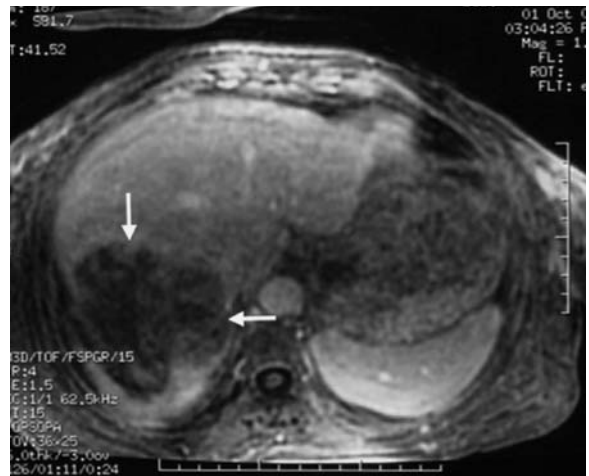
Axial, gadolinium-enhanced MRI of the liver of the same patient as in Fig. 10.7 after two TACE treatments shows a dramatically decreased in size tumor with decreased enhancement (arrows). Though many tumors may not decrease in size significantly after TACE, most will show a degree of necrosis as measured on contrast-enhanced MRI
